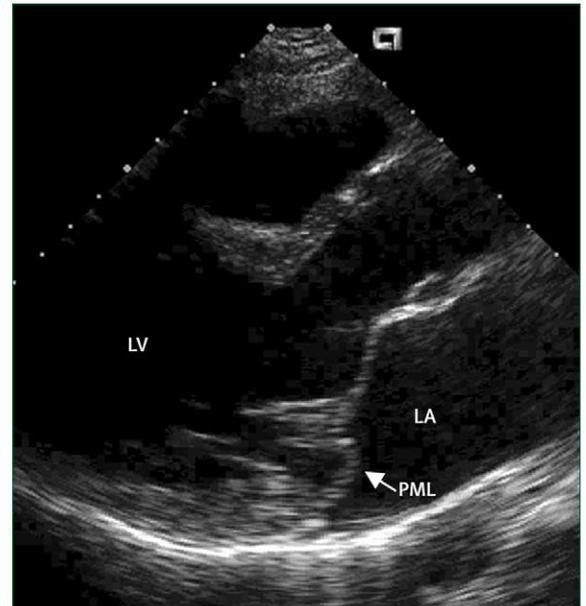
Transthoracic echocardiographic image in parasternal long-axis view, showing posterior mitral leaflet bowing backward and prolapsing into left atrium during systole
